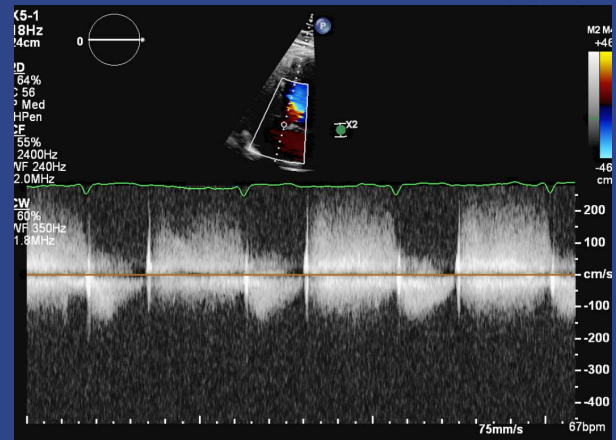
Apical CW Doppler across surgical AV, from author's clinical collection, di-identified (M.Trump, 2025)
